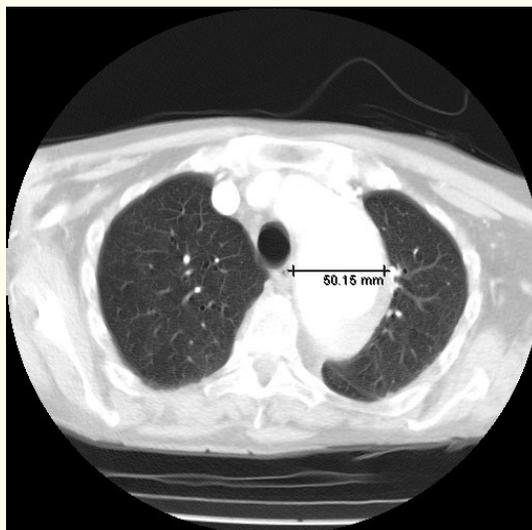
Non- dissected aneurysm of aortic arch (CT).
